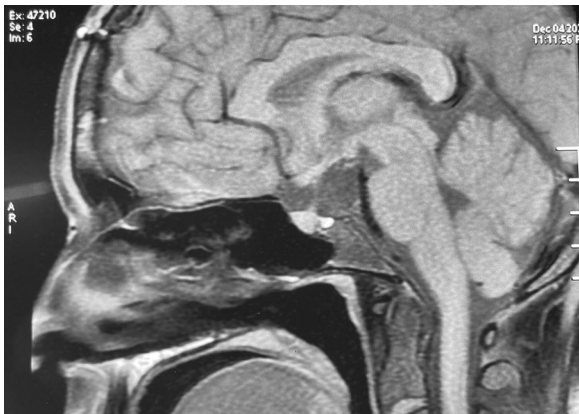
Post-operative MRI sagittal section showing complete removal of the lesion
